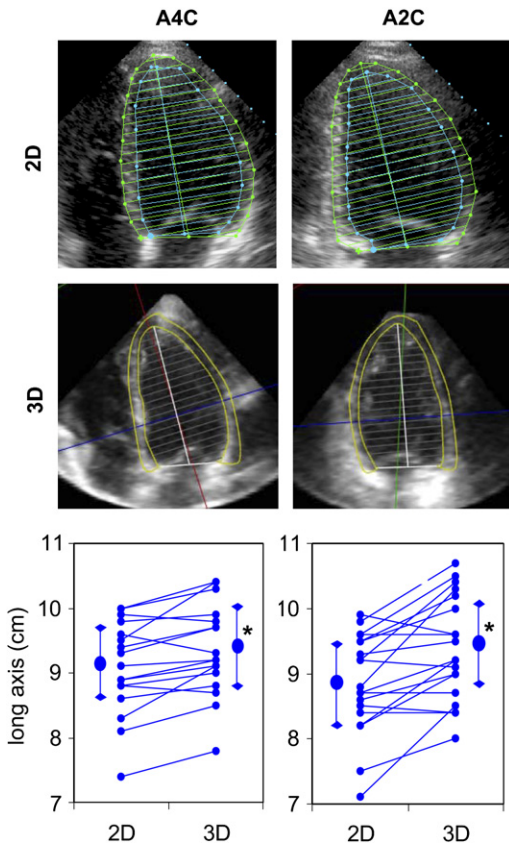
Effects of volumetric imaging on the accuracy of LV mass measurements. End-diastolic apical four- and two-chamber views of the left ventricle obtained in a patient using conventional 2D imaging (*top*) and anatomically correct apical four- and two-chamber cut-planes selected from a real-time 3D dataset obtained in the same subject (*middle*). Manually traced endocardial and epicardial boundaries used to calculate LV mass are shown on the images. Left ventricular long axis dimension measured on such images in 19 patients (*bottom*). Note the increase in the length of the left ventricle in both apical views, as assessed by the 3D technique in most patients (large circles and error bars represent mean \pm SD, $*P < .05$). (Reproduced from Mor-Avi V, Sugeng L, Weinert L, et al. Fast measurement of left ventricular mass with real-time 3D echocardiography; comparison with magnetic resonance imaging. *Circulation* 2004;110:1814–8; with permission.)
